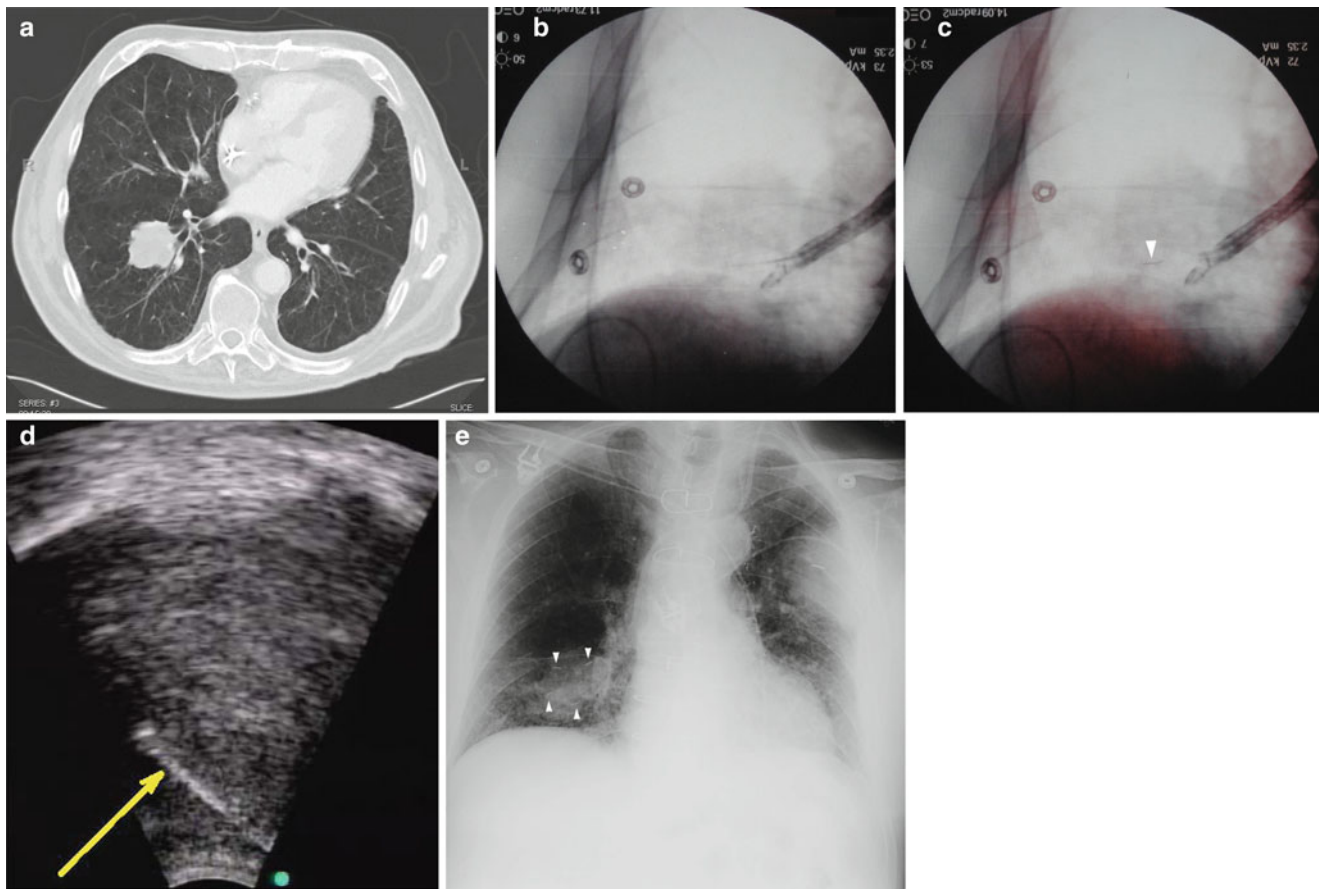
This figure demonstrates implantation of a fiducial in a central tumor using endobronchial ultrasound guidance. *Panel A* shows cross-sectional CT image of the tumor target. *Panel B* shows a posterior-anterior fluoroscopic image of a standard 22-gauge TBNA needle (NA-201SX-4022, Olympus America, Inc., Center Valley, PA, USA) preloaded with a 0.35 mm coiled wire fiducial being passed through an
